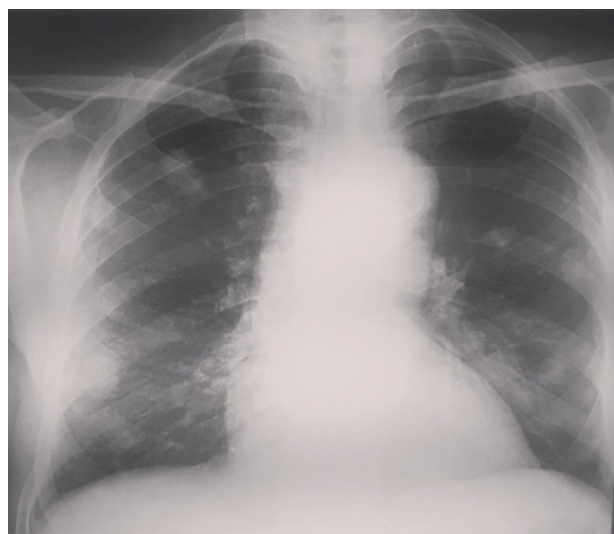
Chest radiographs show multiple well-defined lung nodules.
